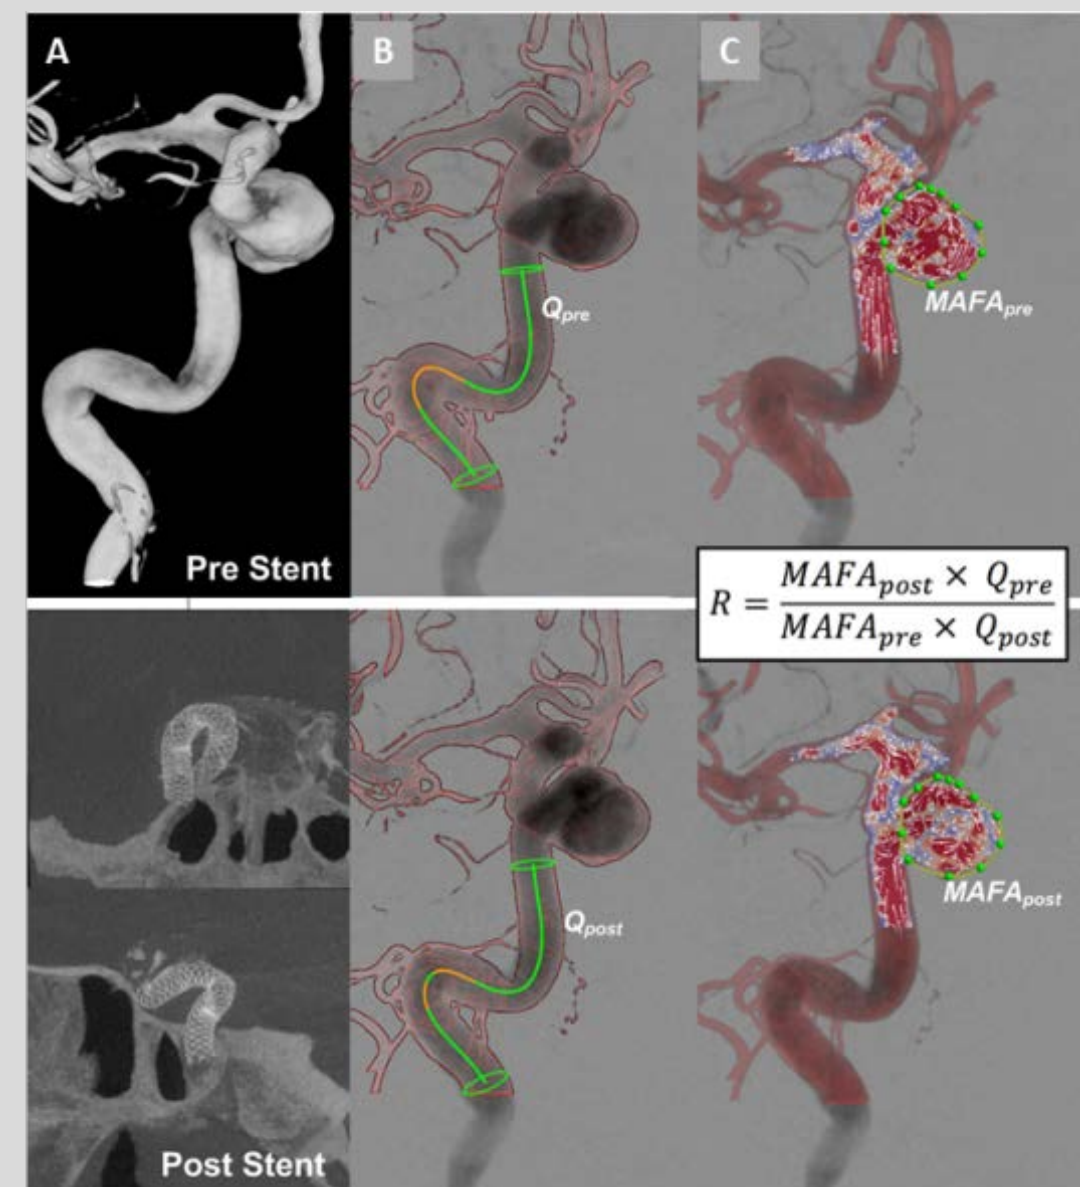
Arterial and aneurysmal flow calculation. A-First row: 3D image of a carotid ophthalmic aneurysm. A-Second row: Post implantation cone-beam CT (AP and lateral) showing a deployed FDS. B, C: Representation of successive steps leading to MAFA ratio calculation for both pre- (first row) and post- (second row) stent acquisitions. B: Vessel segment used for the volume flow rate calculation on co-registered 3D and DSA image C: Representation of the projected velocity fields with their respective MAFA values computed within a region of interest.
